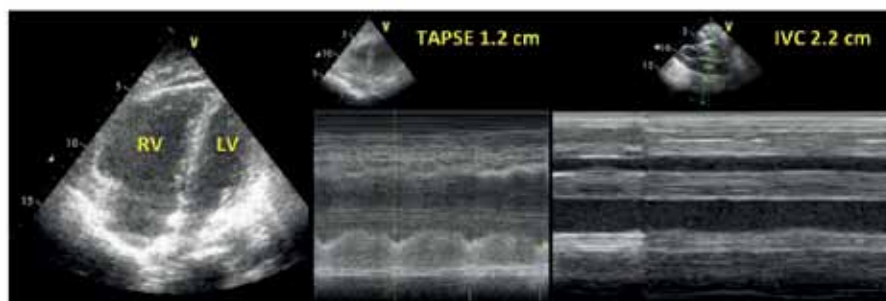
From left to right: transthoracic apical four chamber view showing a failing right ventricle (RV), which appears larger than the left ventricle (LV); the tricuspid annular plane systolic excursion (TAPSE), a marker of RV contractility, is severely reduced (1.2 cm); inferior vena cava (IVC) is distended and fixed (diameter 2.2cm), with no significant variation in m-mode during tidal ventilation, corresponding to increased RV afterload.
